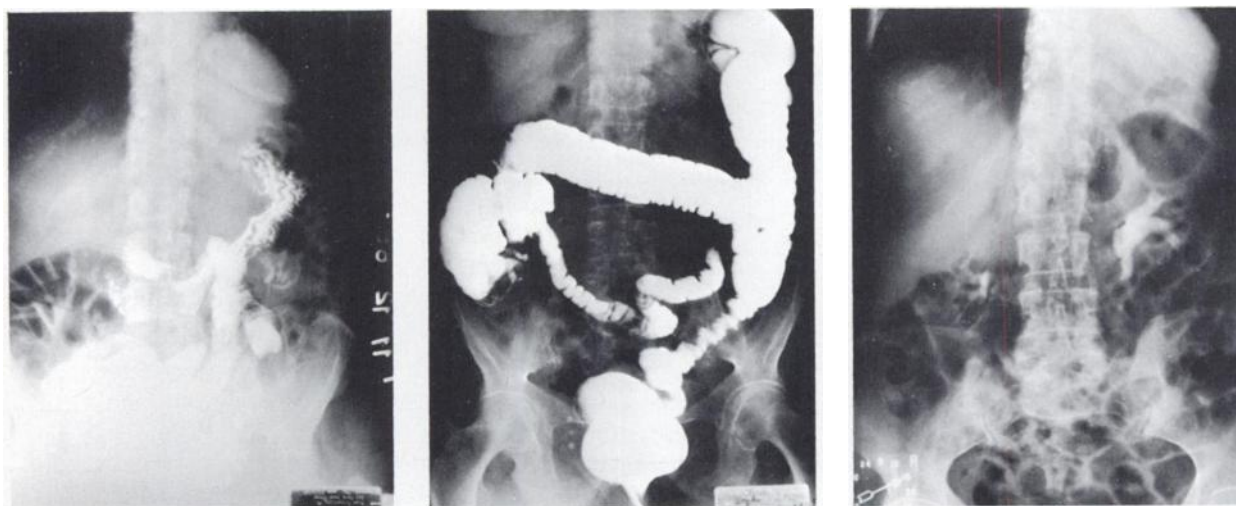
AP supine abdominal roentgenograms shown above indicate that opaque lesion of left lower chest and barium-filled stomach, colon and kidneys are located completely below diaphragm in this patient.
